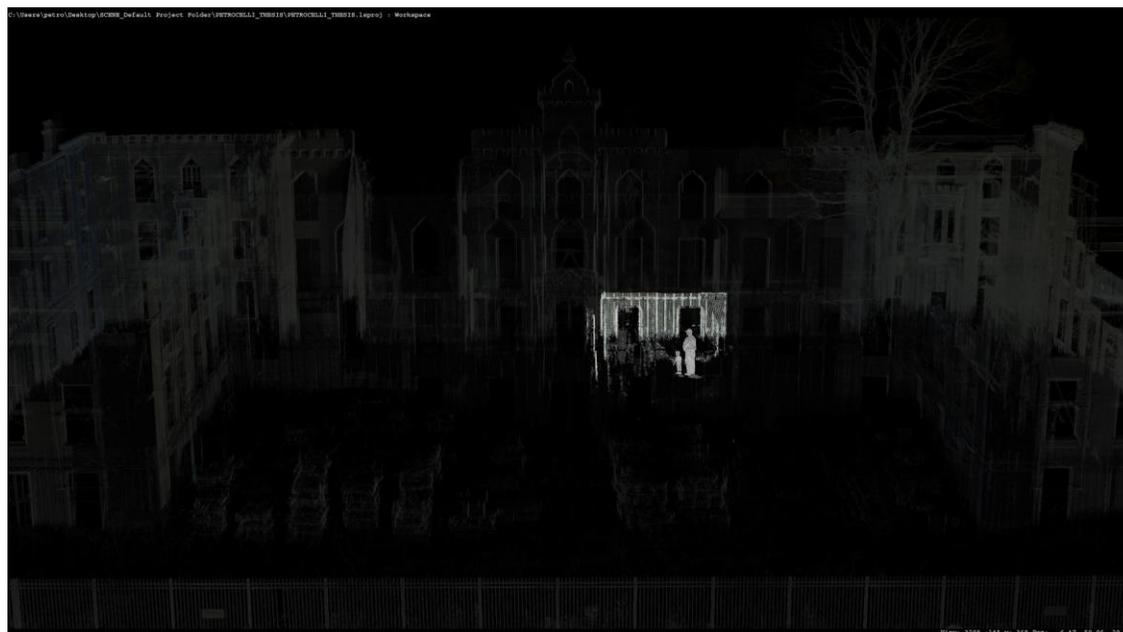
Traces of Inhabitation; Smallpox Hospital Xray
